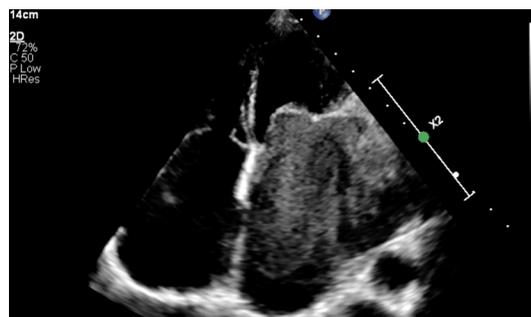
Apical four-chamber view demonstrating severe mitral stenosis with grossly dilated left atrium and dense spontaneous echo contrast.
